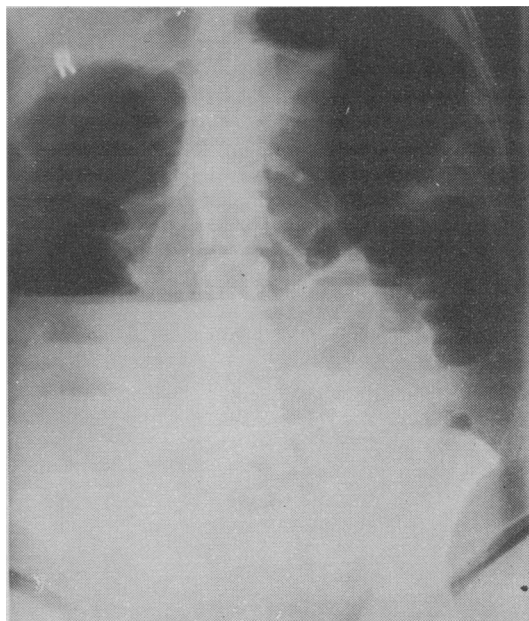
Case 1. Erect x-ray picture of abdomen.
